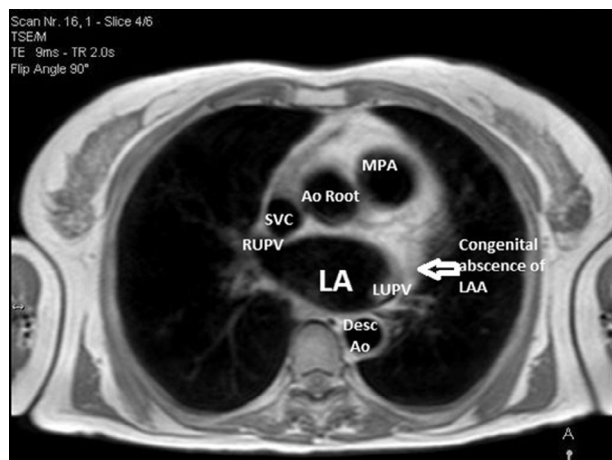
Axial Black blood cardiac Magnetic Resonance Image at the level of LA. Left arrow indicating absent LAA at its normal location. LA indicates left atrium, LAA, left atrial appendage; RUPV, right upper pulmonary vein; LLPV, left lower pulmonary vein; LV, left ventricle; GCV, great cardiac vein; AscAo, ascending aorta; DescAo, descending aorta; PA, pulmonary artery.
